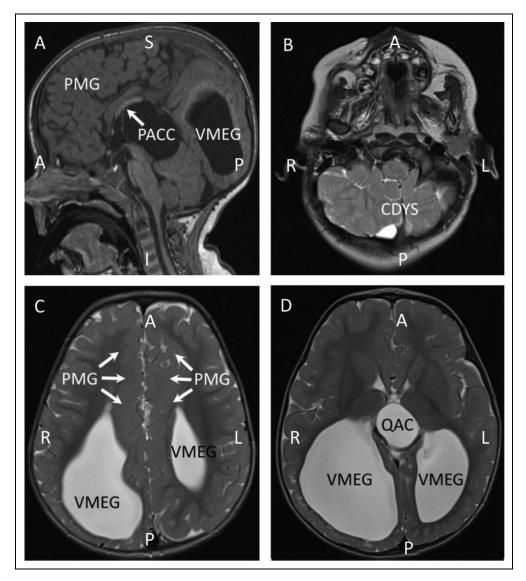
Patient 2 neuroimaging. (A) Midline sagittal T1-weighted magnetic resonance imaging (MRI) and (B, C and D) axial T2-weighted MRI showing extensive parasagittal polymicrogyria (PMG), partial agenesis of corpus callosum (PACC), ventriculomegaly (VMEG), quadrigeminal arachnoid cyst (QAC), and severe cerebellar dysgenesis (CDYS).
